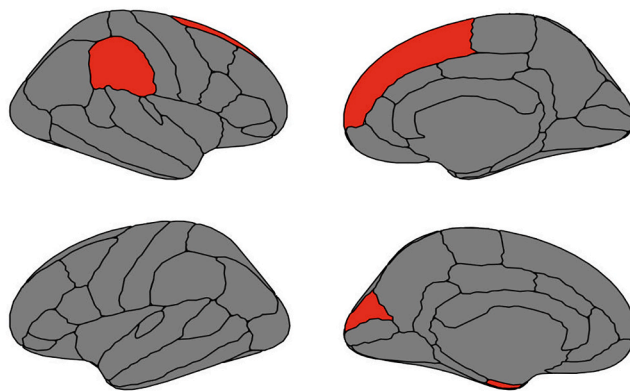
Brain map for brain regions identified in both elastic net regression Model 1 and Model 3 (A), were also significantly associated with anxiety problems in linear mixed effects models (B). Red indicates cortical surface area (CSA) of cortical region, blue indicates cortical thickness (CT) of cortical region, and yellow indicates both CSA and CT of cortical region.
